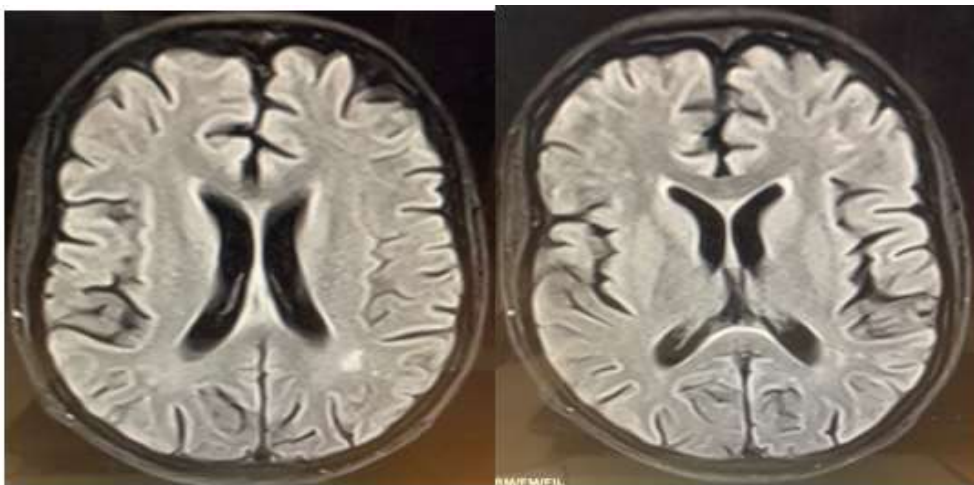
MRI brain shows discrete T2/T2 flair hyperintensities in periventricular and deep white matter in bilateral parietal areas.
